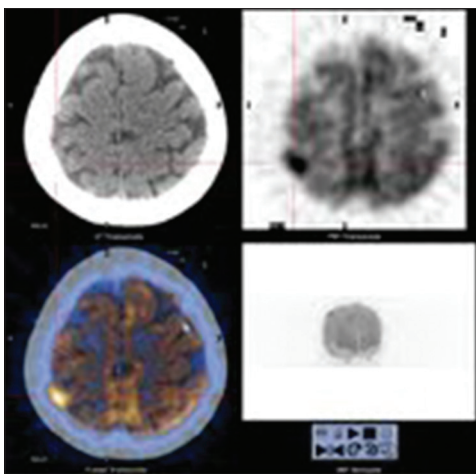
81 year old female with right lower lobe lung cancer. Dedicated brain positron emission tomography/computed tomography series showed FDG avid brain metastasis at right high parietal region, maximum standardized uptake value up to 13.0
